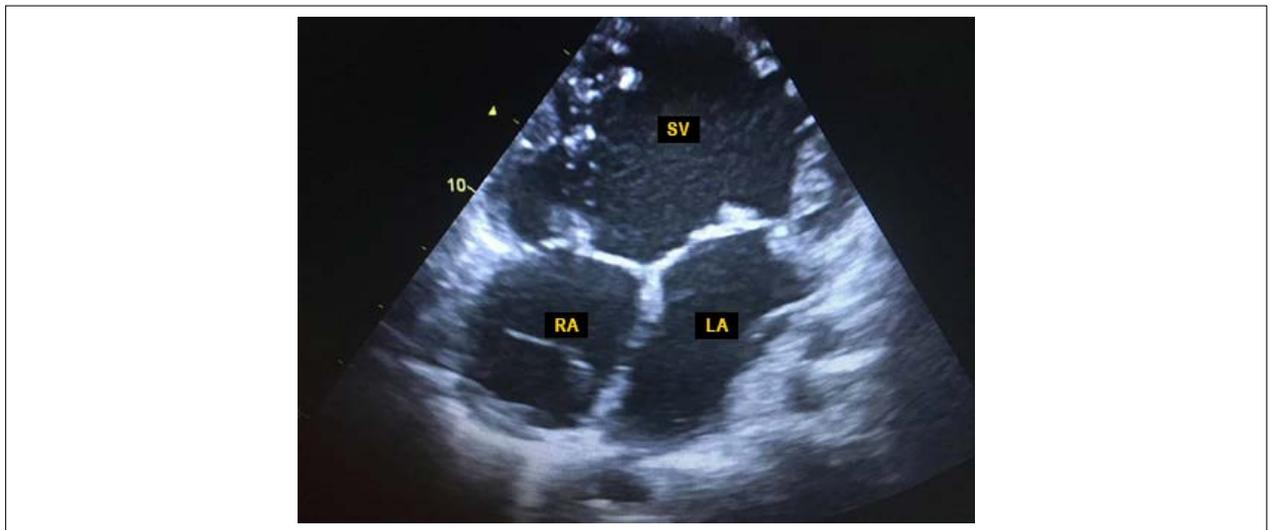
Transthoracic echocardiography: apical view, showing single ventricle and no evidence of recorded interventricular septal tissue. 254x190mm (96x96 DPI).
